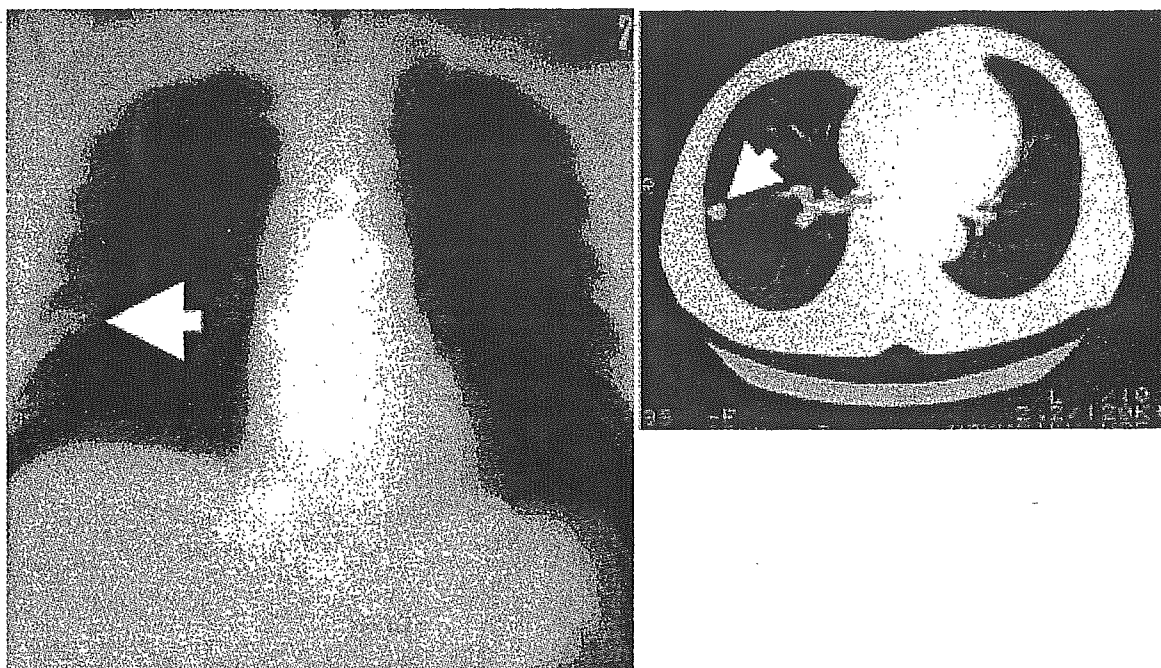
Chest X-ray (left) and CT (right) appearance of a patient with pulmonary dirofilariasis. A solitary nodule called “coin lesion” is adjacent to the pleural membrane (arrow).
